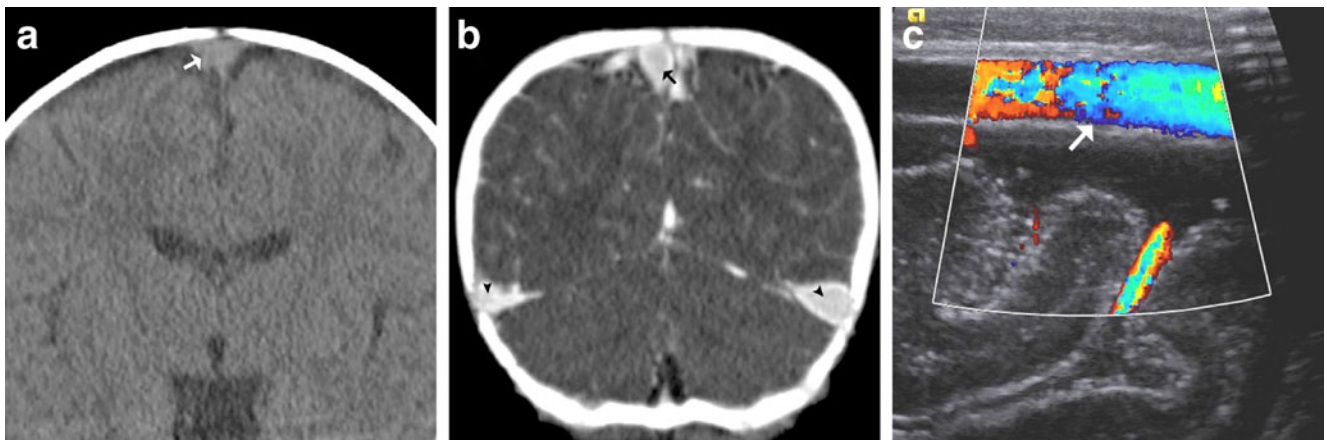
Pseudovenous thrombosis in a 12-month-old girl with macrocephaly. a Coronal reformation from unenhanced CT shows homogeneous slightly hyper-attenuating superior sagittal sinus (*arrow*). b Coronal reformation from CT venography demonstrates low-attenuation regions within the central superior sagittal venous sinus
